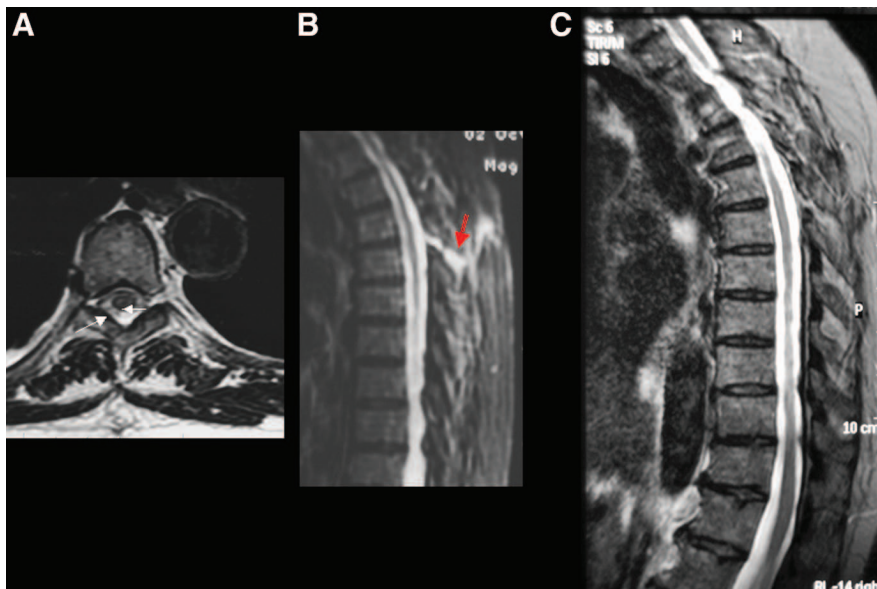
Significant reduction in the posterior thoracic epidural abscess in axial T2-weighted image (A) and persistence of the linear hyperintense signal in the posterior paravertebral soft tissues in sagittal short T1 inversion recovery (STIR) (B) (red arrow). Complete disappearance of the abscess and fistula tract in the final study (C).
